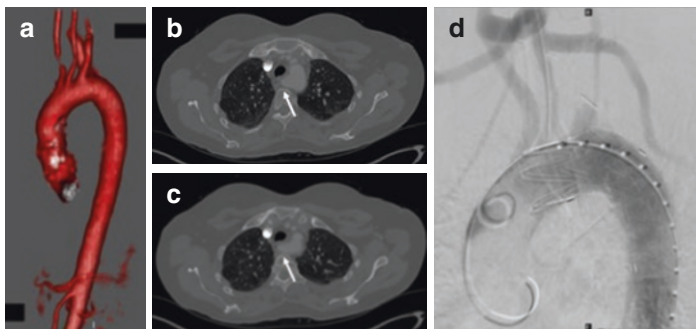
Aberrant right subclavian artery. (a) 3D reconstruction of patient with aberrant right subclavian artery. (b, c) CT Angiogram of the chest. White arrow indicates retroesophageal right subclavian artery. (d) Digital subtraction angiography showing patient anatomy after prior aberrant right subclavian artery to right common carotid artery transposition with proximal ligation followed by left subclavian to left common carotid artery transposition and TEVAR several years later for persistent dysphagia symptoms
